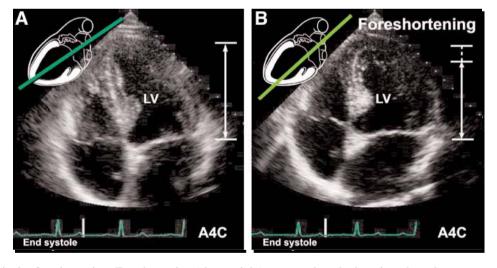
Left ventricular foreshortening. Foreshortening (shown right) occurs when the imaging plane does not transect the center of left ventricular apex (left). It is a common source of error in left ventricular quantification in two-dimensional echocardiography. (Please *see* companion DVD for corresponding video.)
